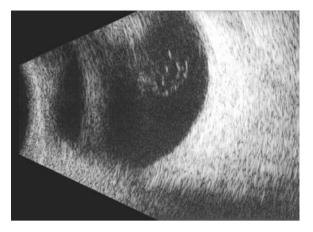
Patient 2. Residual noninfectious vitreous opacities seen on B-scan ultrasonography
